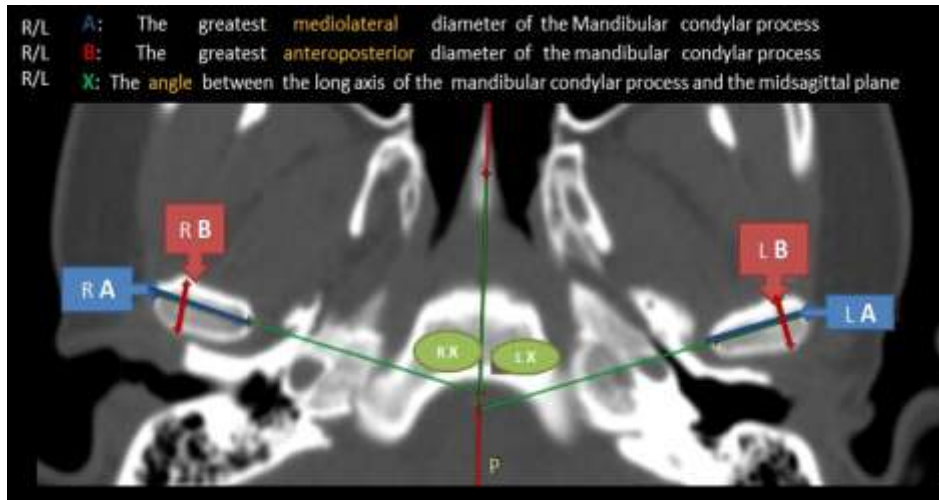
CT image representing: a, greatest mediolateral diameter of the mandibular condylar process;b, greatest anteroposterior diameter of the mandibular condylar process; X, lateromedial plane angle of the condylar process/ midsagittal plane ,MSP, midsagittal plane.
